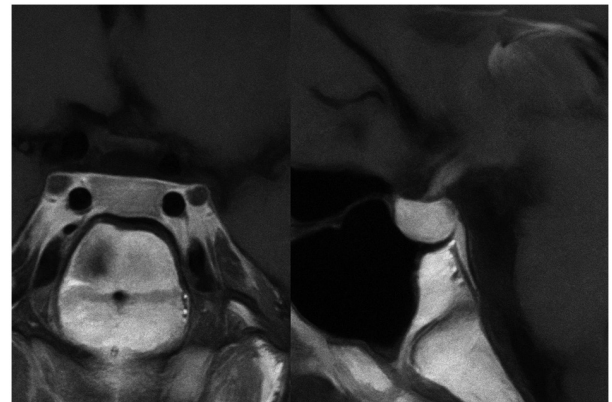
Pituitary gland in the coronal (left) and sagittal (right) sections on the T1 sequence on magnetic resonance imaging.
